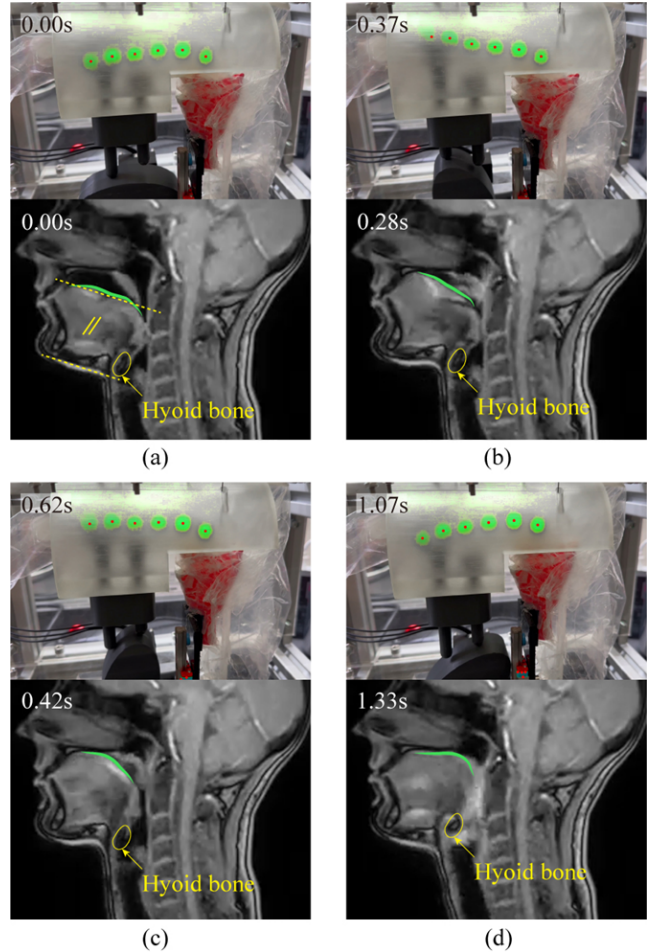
Comparison of artificial and real tongue during swallowing. (a) the dorsal surface of the tongue exhibits a slight inverted-U profile, with its mid-section elevated above both the tip and the root. In the MRI, this appears as the mid-section lying above a plane parallel to the mandibular plane at the tongue surface, while the tip and root lie below that plane. (b) the tip of the tongue in both the prototype and the MRI are elevated. (c) the midsections of the tongue in both the prototype and the MRI are elevated. (d) the larynx rises in both images, elevating the tongue root against the palate.
